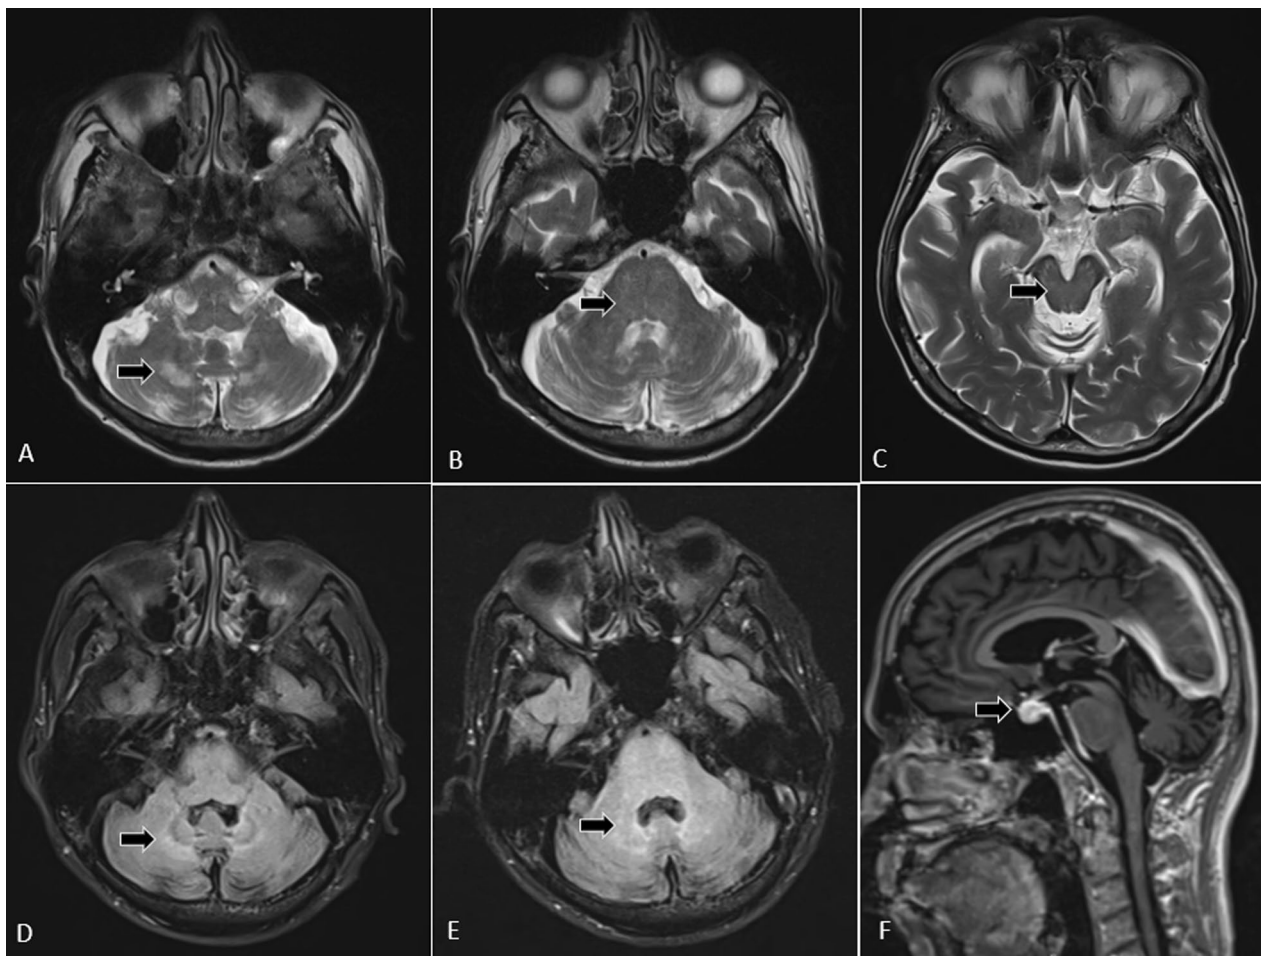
Magnetic resonance imaging of brain in a 60-year-old male patient diagnosed with Erdheim–Chester disease reveals hyperintense signal in pons, midbrain, cerebellum and bilateral middle cerebellar peduncles on T2W axial images (A–C) and FLAIR images (D, E). The post-contrast T1 sagittal image (F) shows enlarged homogeneously enhancing pituitary gland
